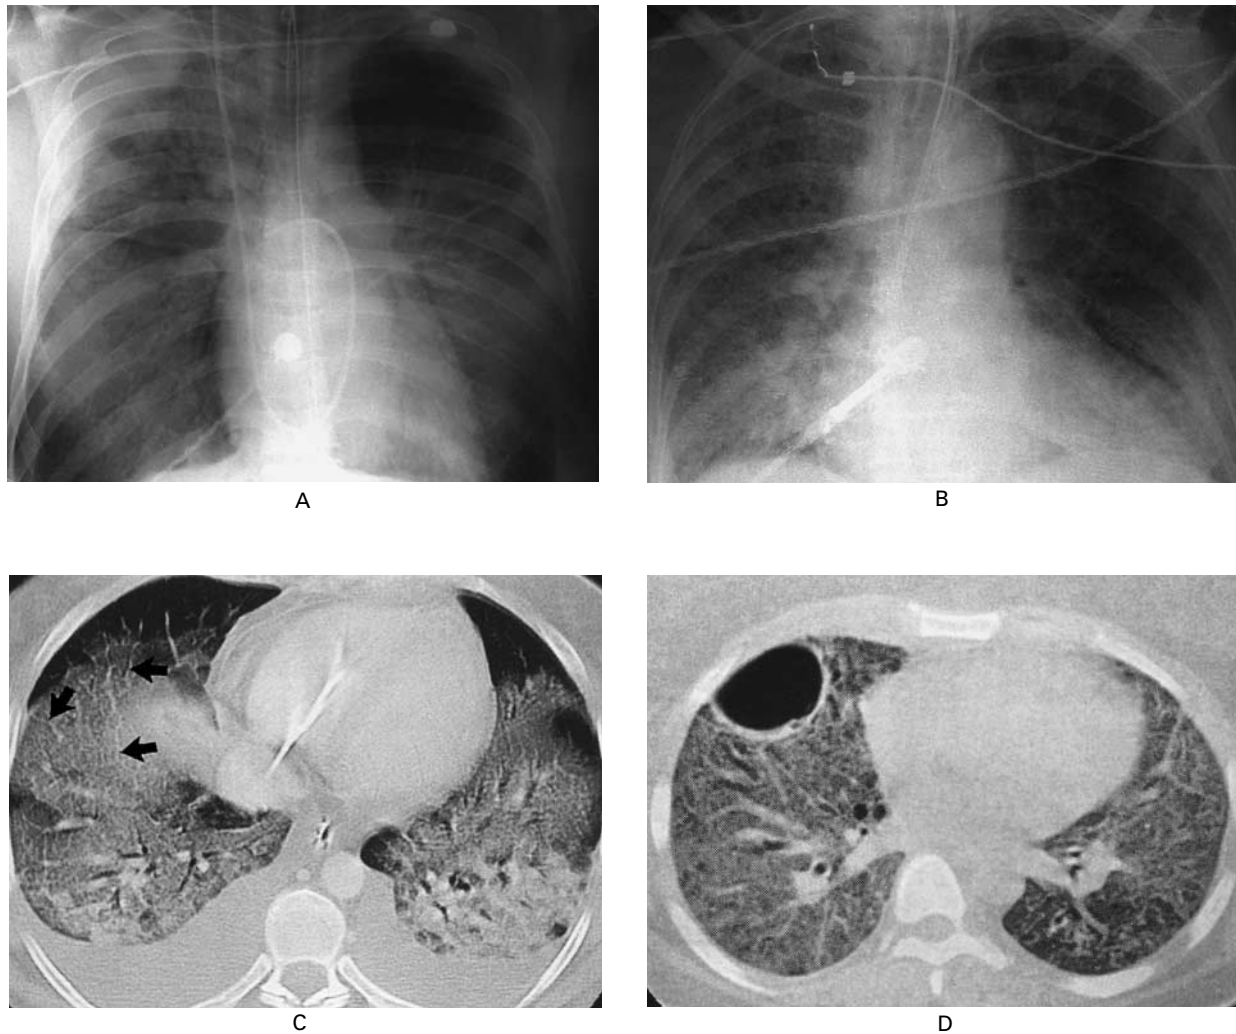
Radiographic and Computed Tomographic (CT) Findings in the Acute, or Exudative, Phase (Panels A and C) and the Fibrosing-Alveolitis Phase (Panels B and D) of Acute Lung Injury and the Acute Respiratory Distress Syndrome.
